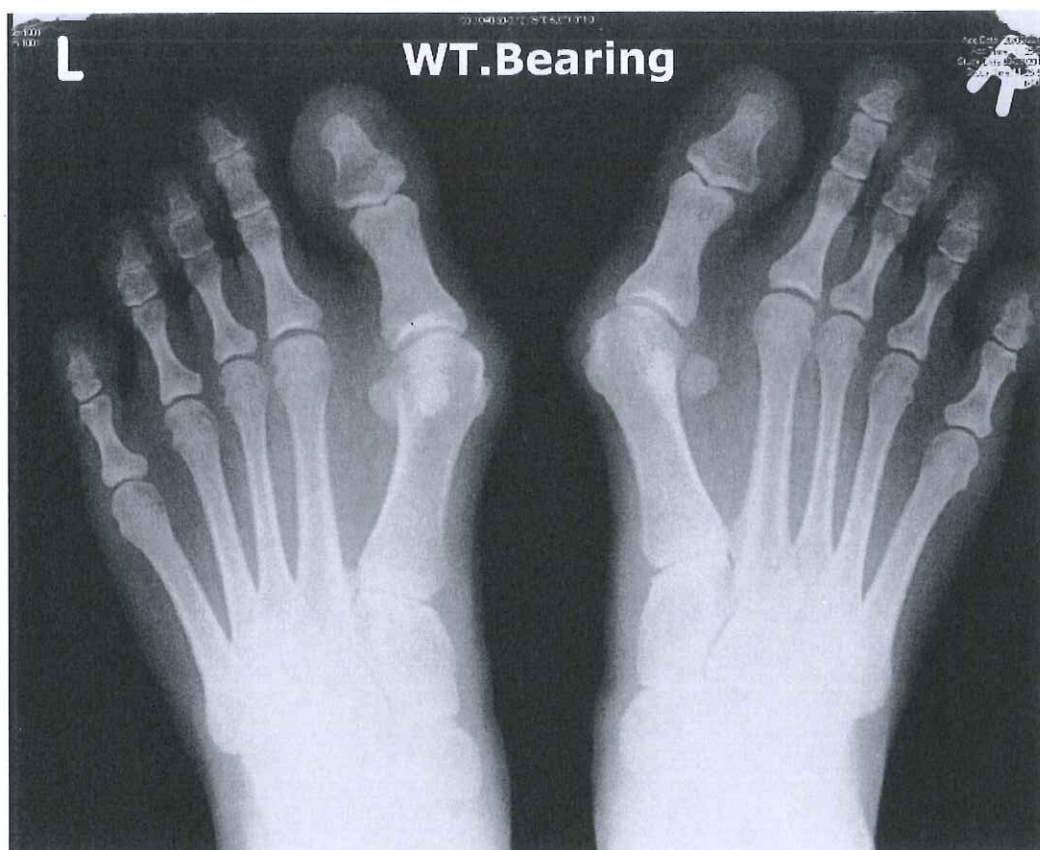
X-ray of the feet of the 26-year-old banker.
